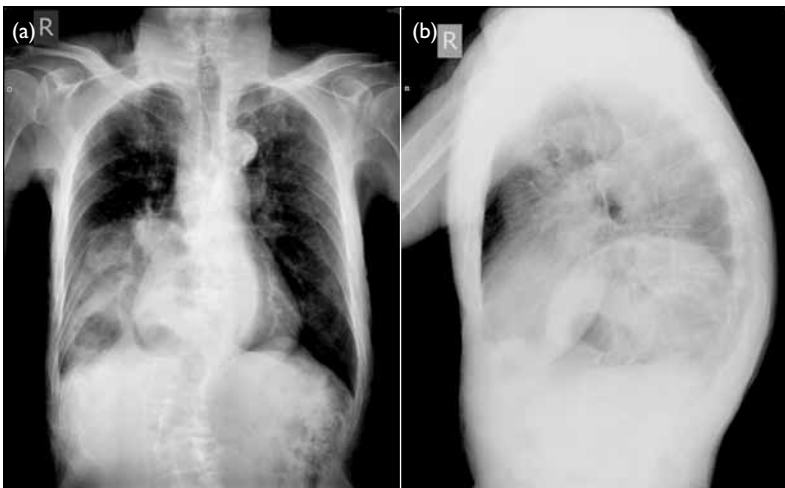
(a) Posteroanterior chest X-ray and (b) right lateral chest X-ray show the bowel loops situated over the lower zone of the right hemithorax and thoracic scoliosis. Right costophrenic angle in the frontal projection and posterior costophrenic sulcus in the lateral projection are not blunted as in patients with pleural effusions
